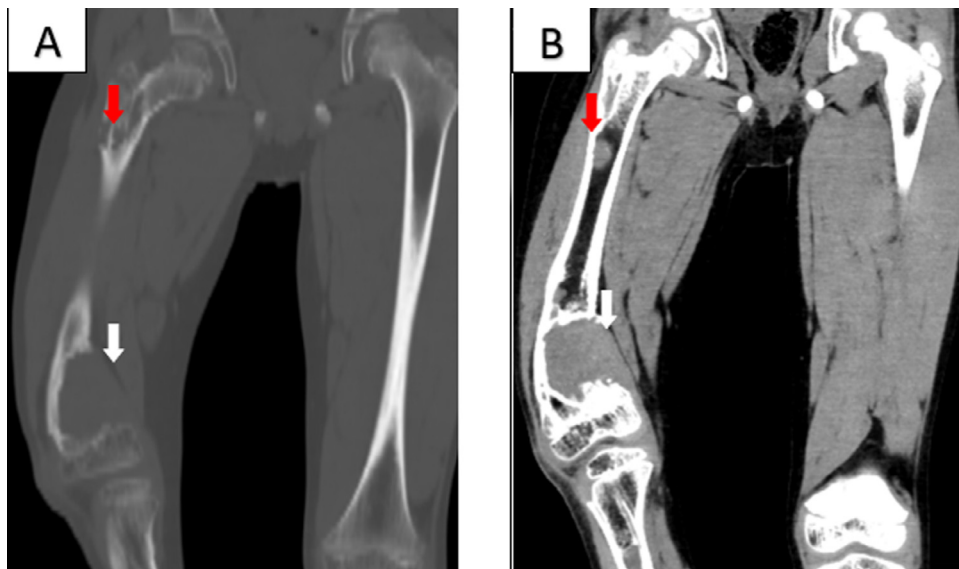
Axial/coronal/sagittal CT images demonstrating an osteolytic lesion of the distal metaphysis of the femur that is well-defined with irregular contours and is responsible for a medullary enlargement with a blown aspect of the cortex that is ruptured on the medial aspect (white arrow). No periosteal reaction or soft tissue invasion was found otherwise. Incidental ipsilateral osteolytic lesions are depicted in the upper femoral shaft (red arrow).
